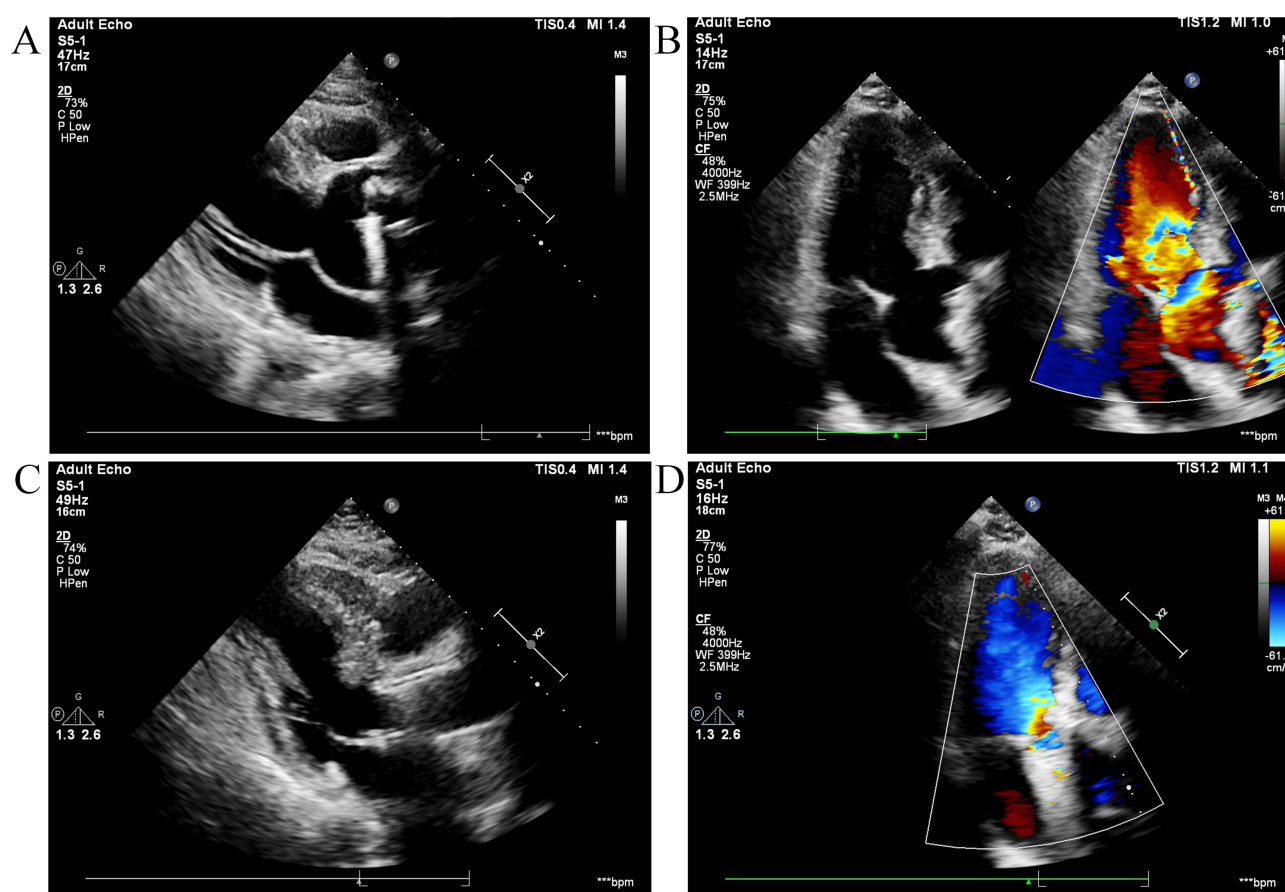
(A–D) Transesophageal echocardiography results before and after surgery. (A) Artificial aortic valve detached from the intrinsic aortic annulus. (B) Significant paravalvular regurgitation. (C) Artificial aortic valve was functioning normally. (D) Normal blood flow observed in the artificial ascending aorta.
